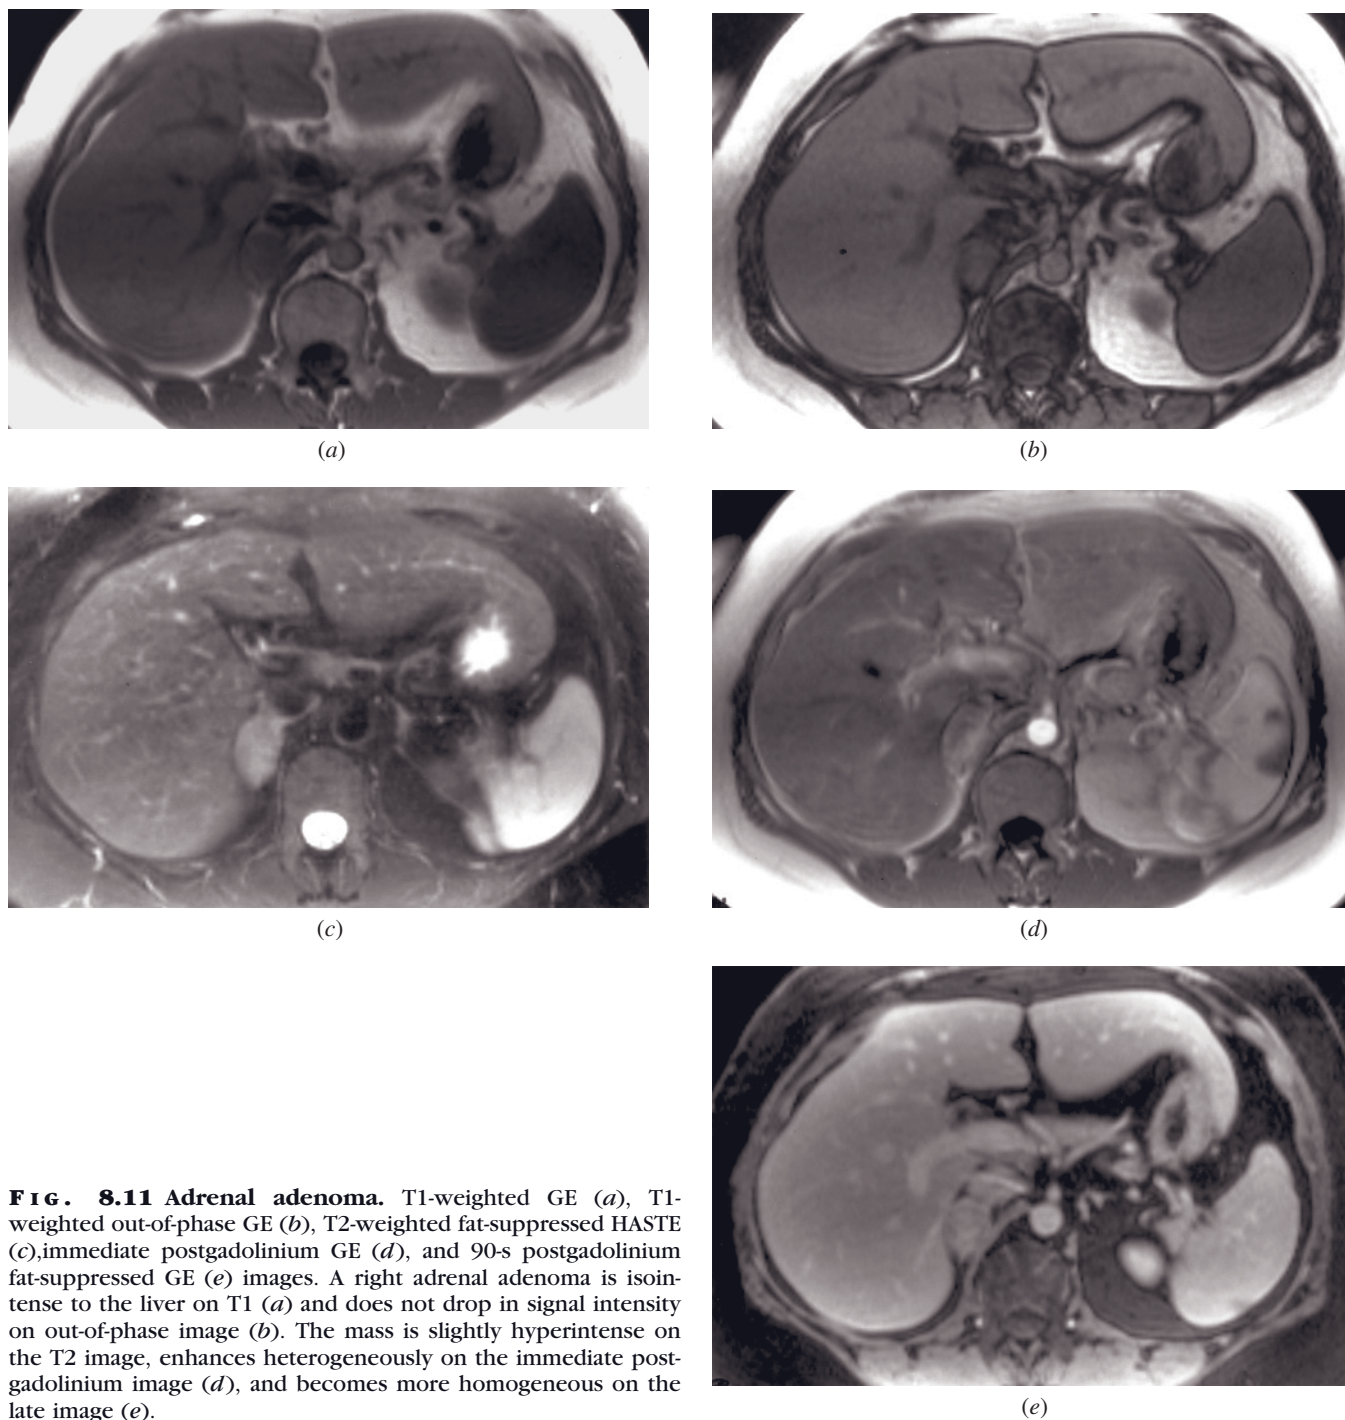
Adrenal adenoma. T1-weighted GE (a), T1-weighted out-of-phase GE (b), T2-weighted fat-suppressed HASTE (c), immediate postgadolinium GE (d), and 90-s postgadolinium fat-suppressed GE (e) images. A right adrenal adenoma is isointense to the liver on T1 (a) and does not drop in signal intensity on out-of-phase image (b). The mass is slightly hyperintense on the T2 image, enhances heterogeneously on the immediate postgadolinium image (d), and becomes more homogeneous on the late image (e).
